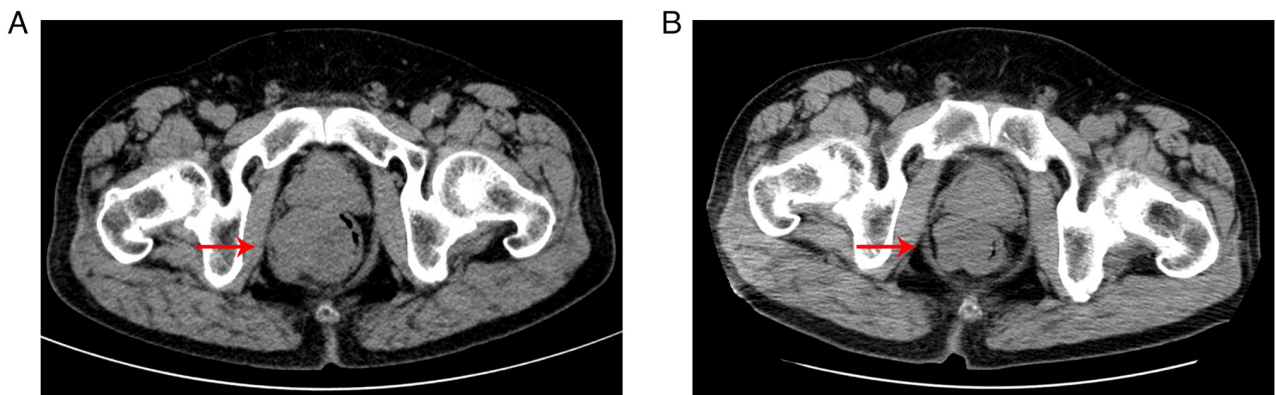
CT. (A) CT in April 2020. (B) Review CT in May 2022. The red arrow points at tumor. CT, computed tomography.
